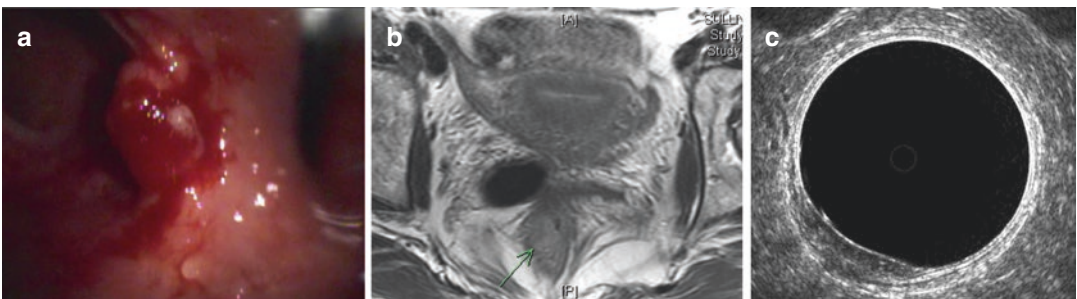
Endoscopic (a), MRI (b) and ERUS (c) images of an early-stage rectal cancer
